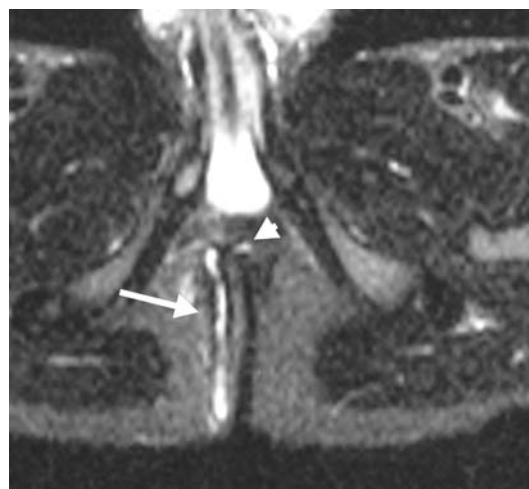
The same patient and plan as presented on the fig. 13 and 14. Axial fat-saturated T2-weighted MR image shows a hyperintense linear lesion recognized as a fistula (*arrow*) in the right perianal fossa. Note an internal opening (*arrowhead*) into the anal canal at 12 o'clock.
